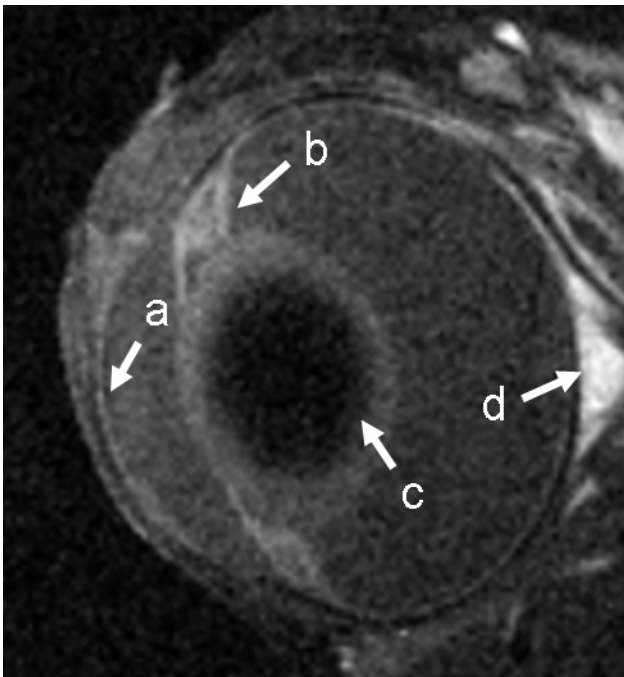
T₁ weighted MR image of the eye in O2 before infusion.
